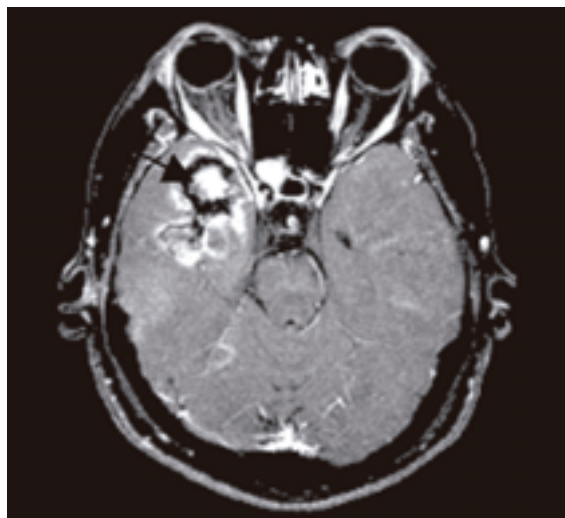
Enhanced axial T1-w MR image shows a enhancing right temporal lobe cyst (arrow).
